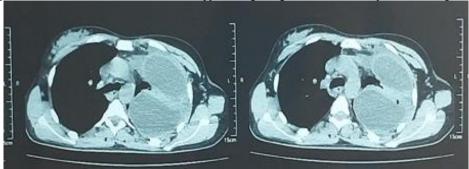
Thoracic CT scan showing two left pulmonary collections.
